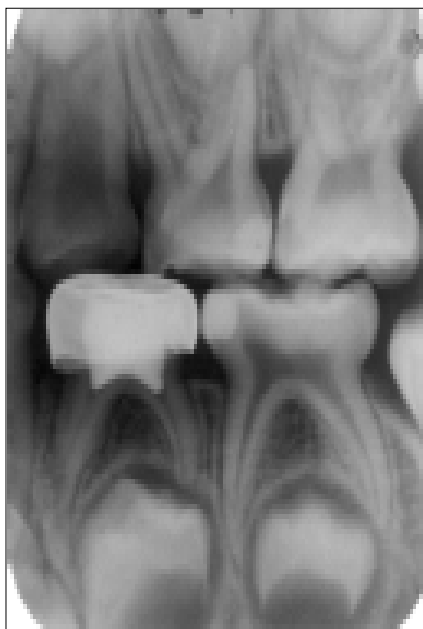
Radiograph of successful treatment of Nd:YAG laser pulpotomy at the nine-month examination. Normal PDL, no radiolucent lesion is found.
